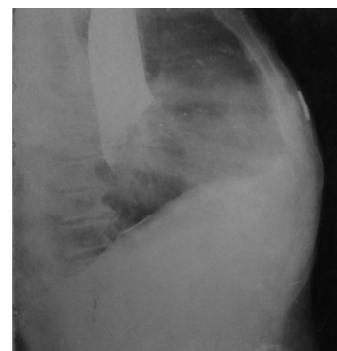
Barium swallow X-Ray of esophagus showing the filling defect
